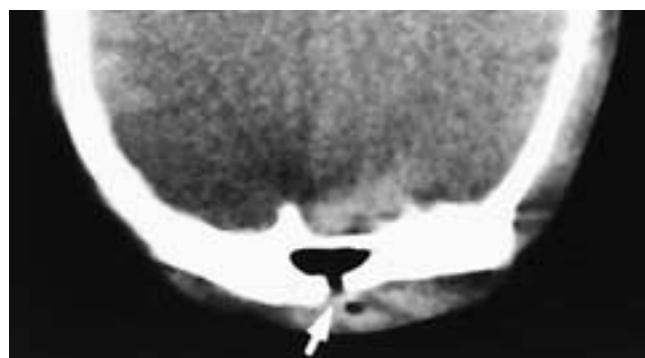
Coronal CT scan shows a frontal sinus that was trephined because of an acute unresponsive sinusitis. The site of the trephination is seen as a hole in the anterior sinus wall (*arrow*).
